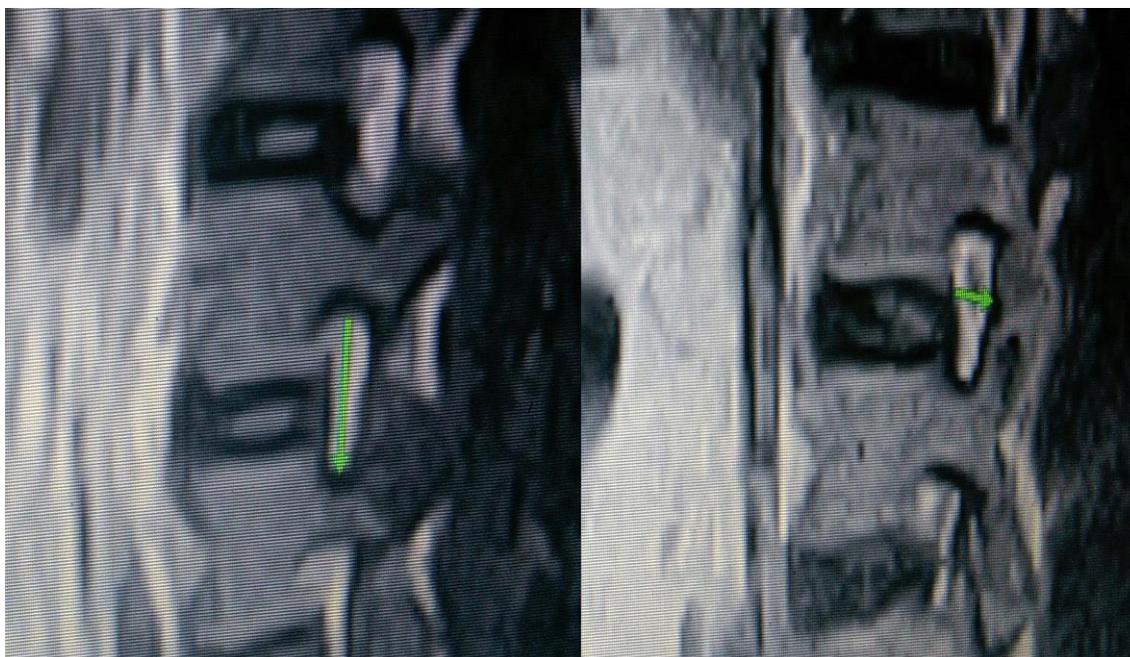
T2 MRI image at L3-L4 level showing: (a) foramen height (H), (b) Foramen Antero Posterior Diameter (APD).
